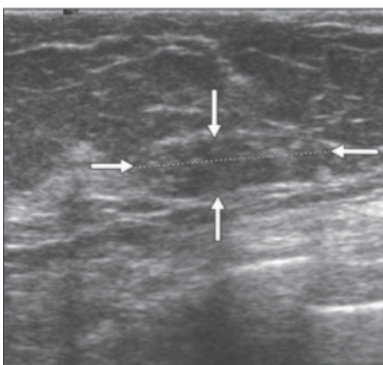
Ultrasound image reveals subtle, hypoechoic, ovoid-shaped, 2cm mass (arrow) containing numerous echogenic foci.
